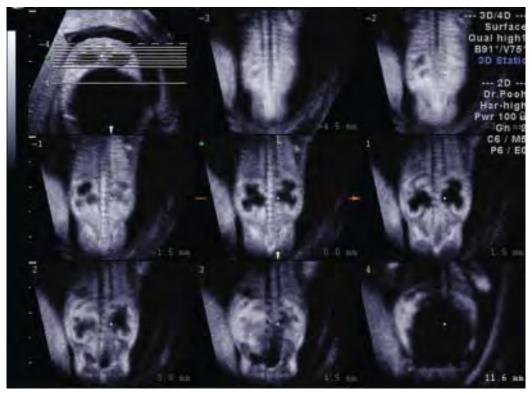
Bilateral hydronephrosis due to posterior urethral valve stenosis at 15 weeks. Tomographic ultrasound coronal image of the bilateral kidneys. Bilateral hydronephrosis with huge bladder occurred due to posterior urethral valve stenosis. Vesicoamniotic shunt at 17 weeks was successfully performed in this case and postnatal course was favorable
